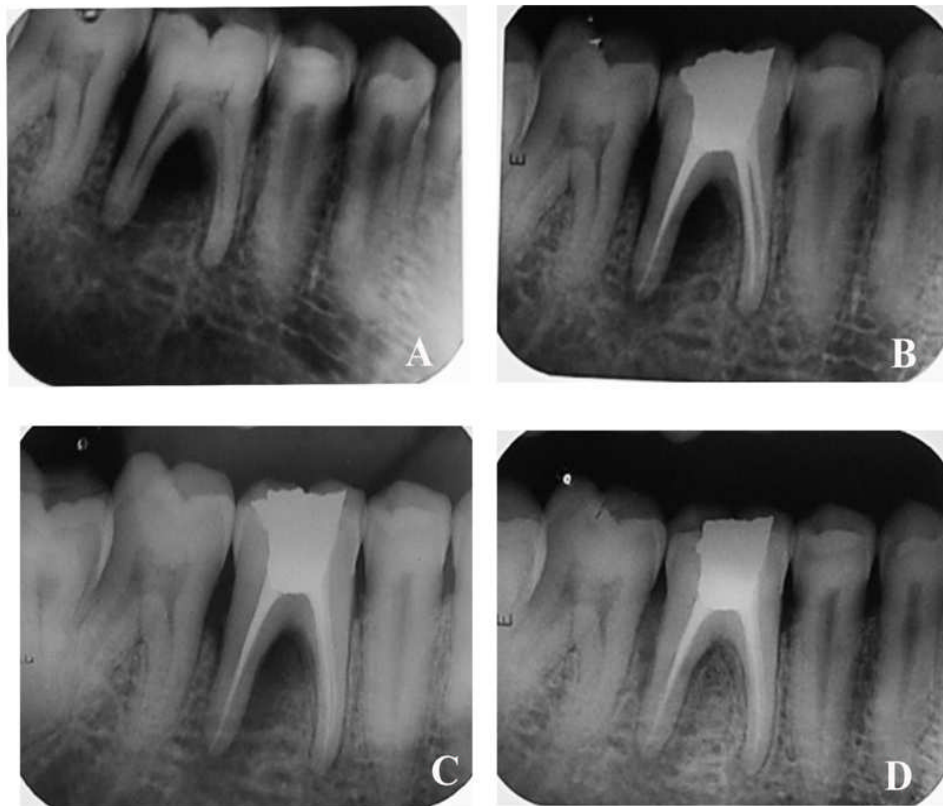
(A) Preoperative radiograph showing showed bone loss around the distal root, and interradicular area of tooth #30. (B) Radiograph taken upon completion of root canal treatment. (C) three month follow up showing periradicular tissues showed sign of regeneration (D) One year follow up radiograph showing evidence of bony healing.
